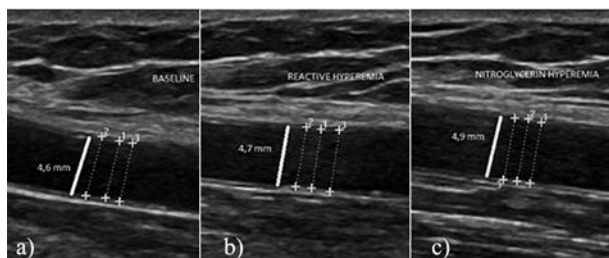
High resolution linear ultrasound measurement of brachial artery diameter a) before stimulus (baseline), b) 1 min after hyperemic stimulus (reactive hyperemia), and c) after nitroglycerin administration (nitroglycerin hyperemia).
